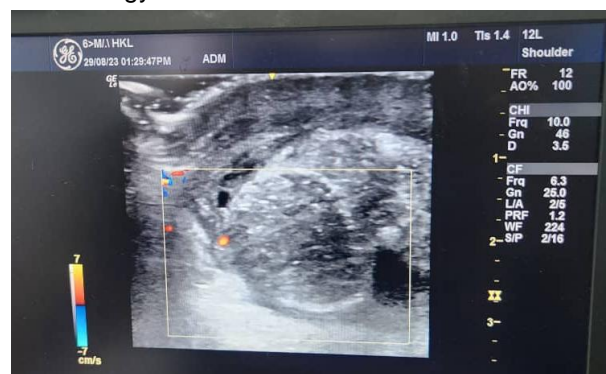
Doppler USG of Right Testis
